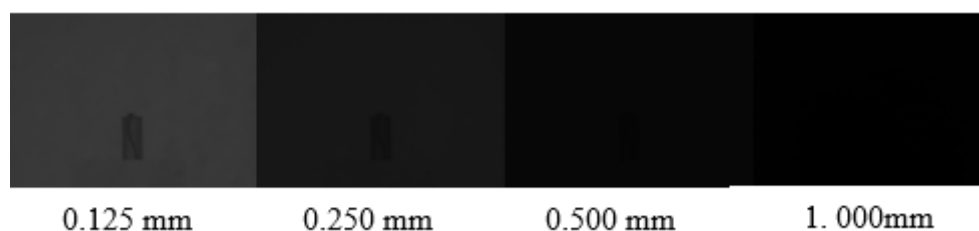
Typical radiographs that were acquired within the tin filter thickness range of 0.1 mm – 2.50 mm, X-ray current of 100 μ A, X-ray tube voltage of 100 kV, FSD of 65 cm and X-ray exposure time of 1 sec.
